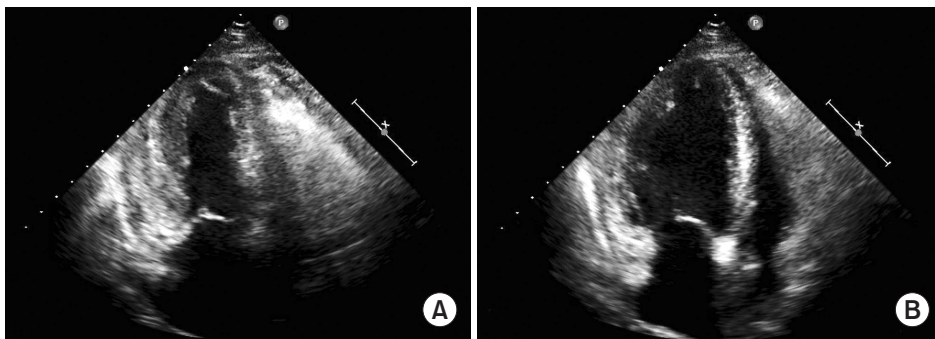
Echocardiogram obtained during systole (A) and diastole (B) on the seventh day after admission. Echocardiogram shows the recovery of the previous wall motion abnormalities.
